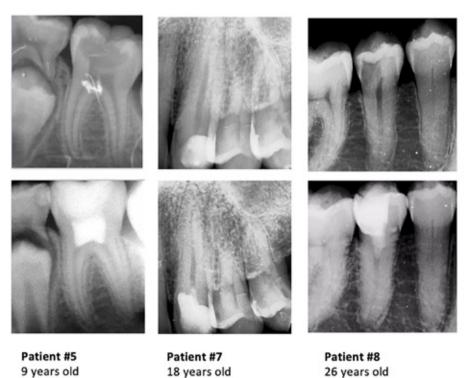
Periapical radiographs of baseline and 12 months follow-up of three patients.
